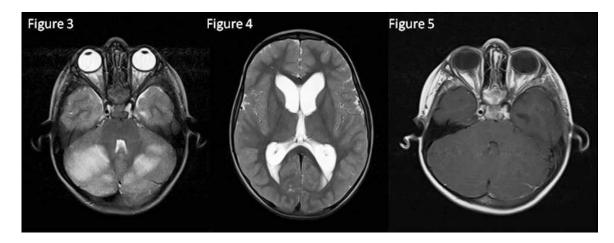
MRI at presentation: T2-weighted axial and post contrast T1-weighted images demonstrating high signal changes in both cerebellar hemispheres, modarate cerebellar swelling with moderate dilatation of the lateral ventricles without contrast enhancement.
